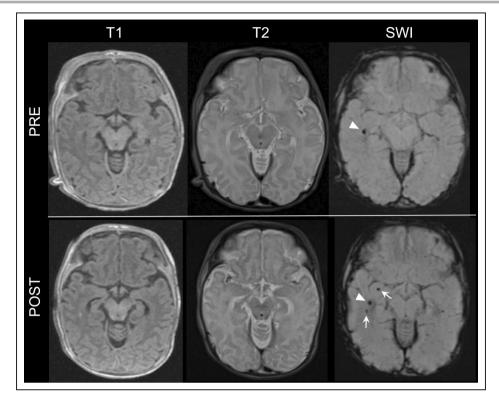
Representative MRI of a single patient with pre- and postoperative CMH. CMH are often not visible on T1-weighted or T2-weighted MRI but are visible on SWI. Arrowheads demarcate CMH present on both preoperative and postoperative SWI. Arrows highlight the accrual of additional CMH on postoperative SWI. CMH indicates cerebral microhemorrhage; MRI, magnetic resonance imaging; POST, postoperative; PRE, preoperative; SWI, susceptibility weighted imaging; T1, T1-weighted MRI; and T2, T2-weighted MRI.
